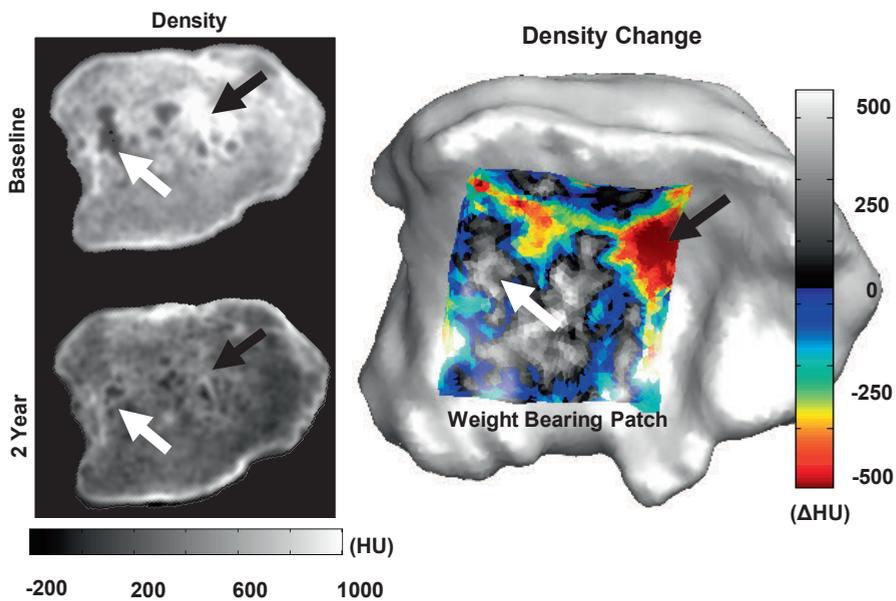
After two years of distraction, the normalization of bone densities is evident on CT (left). The change in bone density (2yr – baseline) in the weight bearing area of the tibia (mean from 1-3 mm depth), right, depicts the increase in density near cysts (white arrow), and a decrease in density in sclerotic regions (black arrow).
